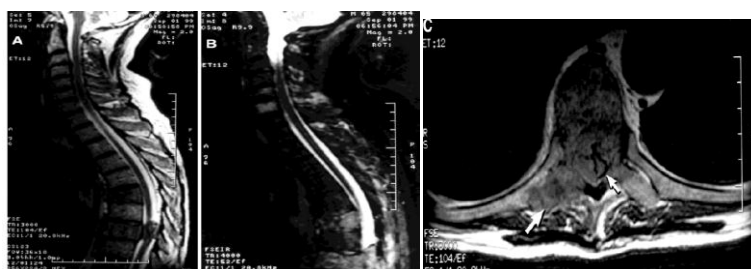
65-year-old male with metastatic rectal carcinoma presented with a two-day history of lower extremity weakness. He had prior spinal radiation to overlapping ports at T8. A) Midline sagittal fast spin echo T-2 weighted image showing compression fracture at T6 and spinal cord impingement at T8. Tumor is not well visualized. B) STIR image reveals multiple levels of spinal tumor seen as hyperintense including the vertebral bodies of C5, C6, T6 and T8. Also noted are several areas of posterior element involvement in the cervical and thoracic spine. C) Axial T1-weighted image shows circumferential high grade epidural tumor with spinal cord compression (small arrow) and lateral extension of the tumor into the epidural space (large arrow).
